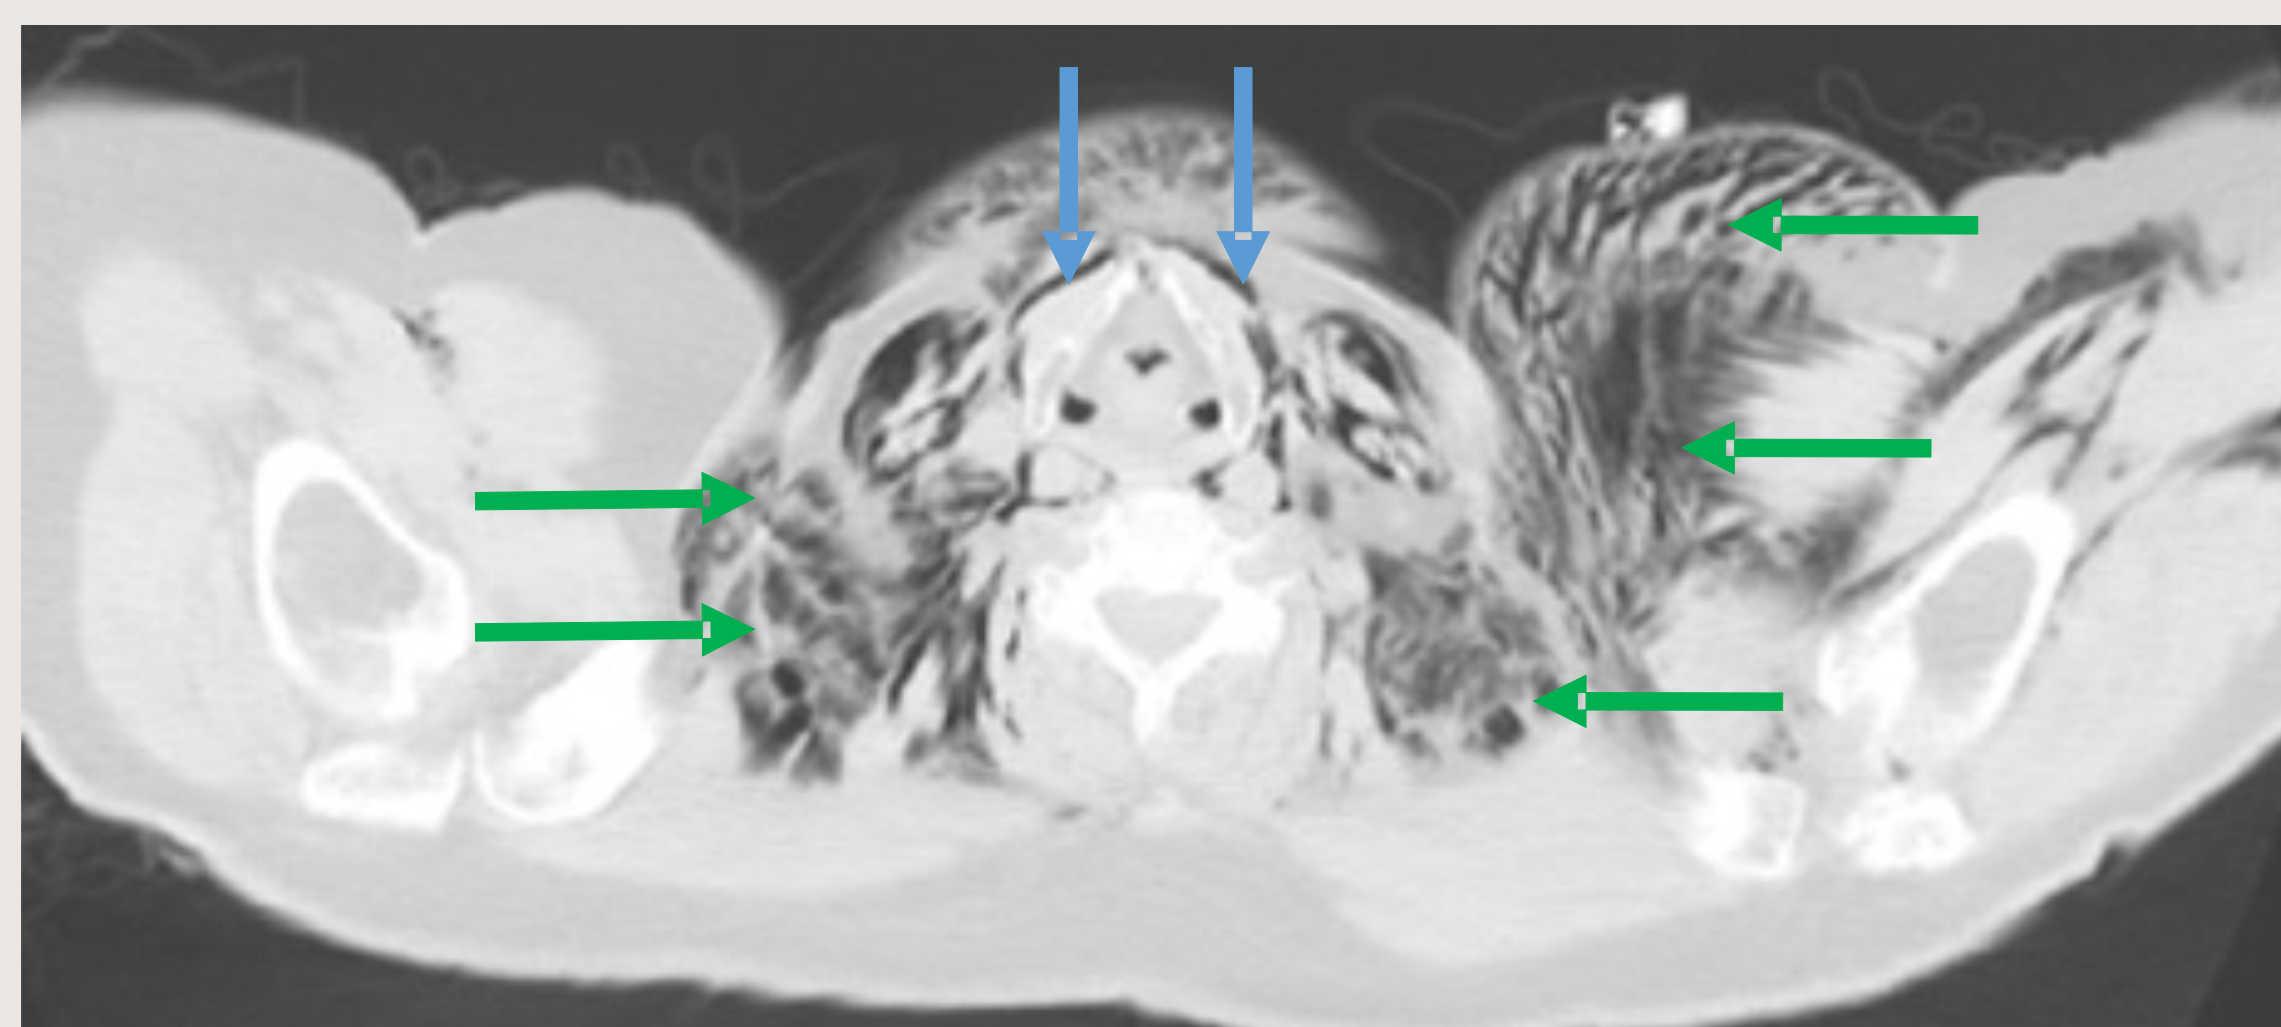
CT chest/neck showing air in mediastinum (blue), and subcutaneous air in neck and chest tissue (green)
